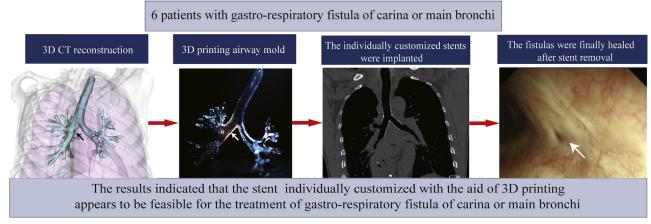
A total of 6 patients with gastrorespiratory fistula of carina or main bronchi underwent implantation of retrievable covered metallic segmented Y airway stent. The stent was individually customized with the aid of 3D printing airway mold, which was made based on 3D CT reconstruction. The stenting procedures were successful, and the fistulas were finally healed after stent removal in all patients. The results indicated that the stent appears to be feasible for the treatment of gastrorespiratory fistula of carina or main bronchi. *3D*, 3-dimensional; *CT*, computed tomography.
